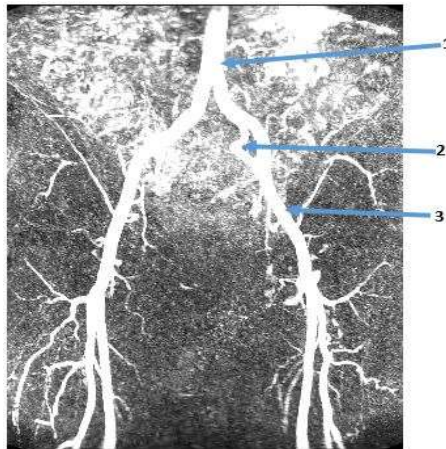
Maximum Intensity Projection (MIP) images of randomly chosen CT pelvic arteriogram. 1. abnormal aorta; 2. internal iliac artery; 3. external iliac artery
